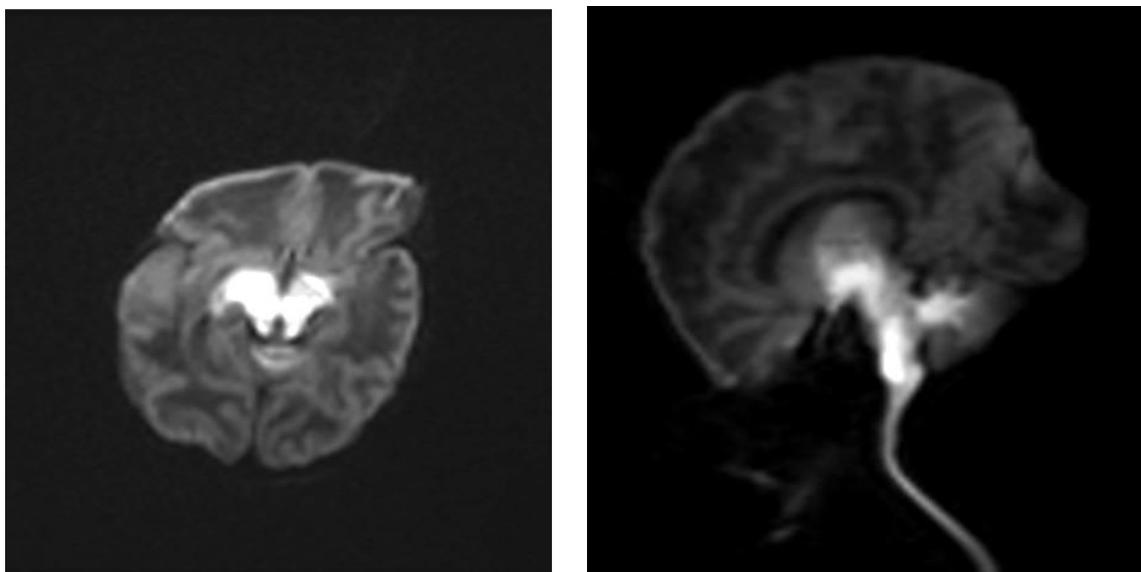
DIFFUSION WEIGHTED MRI Brain show restriction at bilateral thalamus,Midbrain,pons, cerebral peduncles,cerebellar deep white matter.
